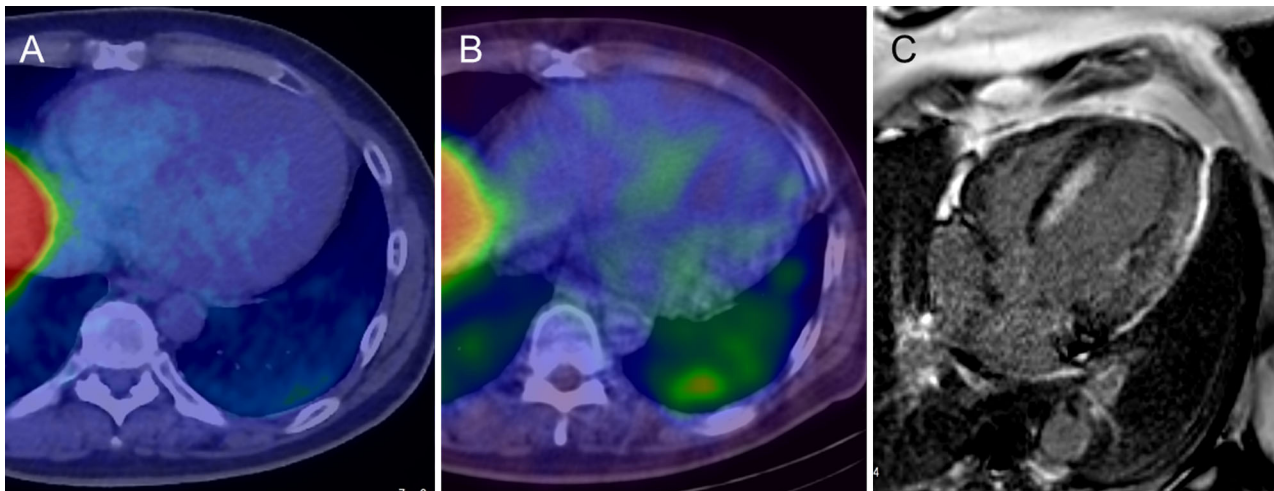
Patient No. 3. A ^{11}C -PIB PET/CT, B $^{99\text{m}}\text{Tc}$ -aprotinin scintigraphy, C Delayed enhanced cardiac MRI image (phase-sensitive inversion recovery) $^{99\text{m}}\text{Tc}$ -aprotinin uptake was identified in septal and lateral myocardial wall, which correspond to the delayed enhanced area in cardiac MRI. However, ^{11}C -PIB PET/CT showed negative findings in entire myocardial wall. Amyloid deposition in patients was not confirmed by cardiac biopsy, and ejection fraction of heart was improved in 11 months.
